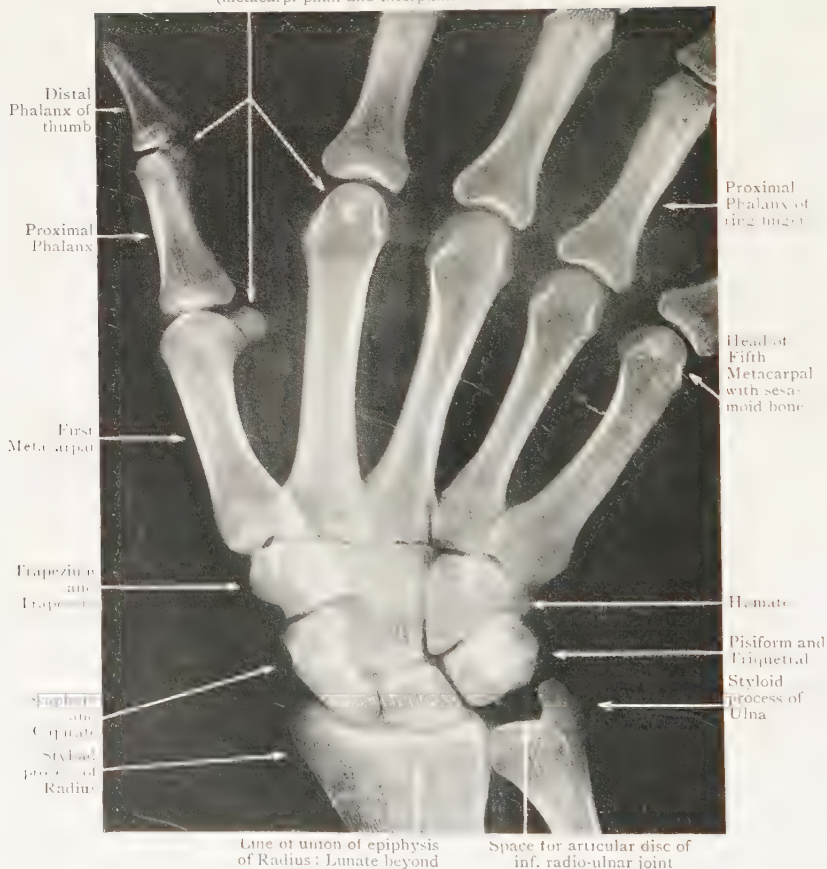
Radiograph of Wrist and Palm of girl aged 17.
